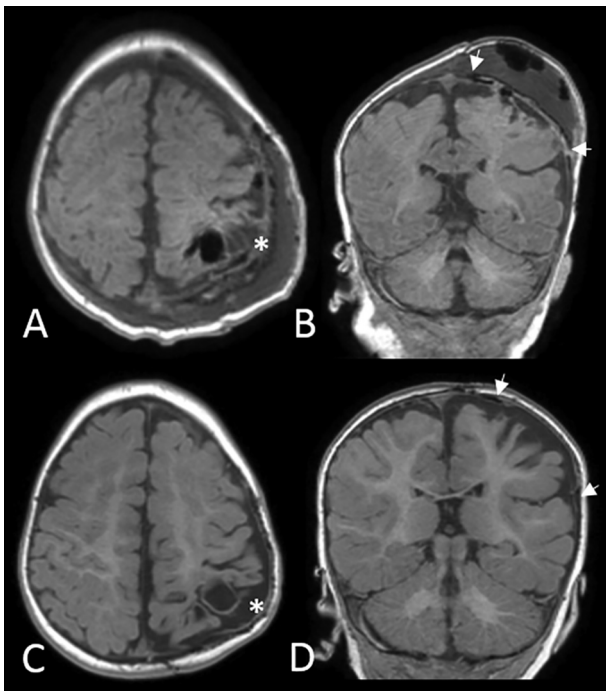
Postoperative axial (A) and coronal (B) T1-weighted MR images show the absence of complications and the correct placement of the mesh (the white star is placed in the contour of the implant in axial plane A and C, white arrows indicate the limits of the implant in the coronal plane B and D). Follow-up axial (C) and coronal (D) T1-weighted MR images performed 3 months after cranioplasty disclose a thinning of the prosthesis and an overall good cosmetic result.
